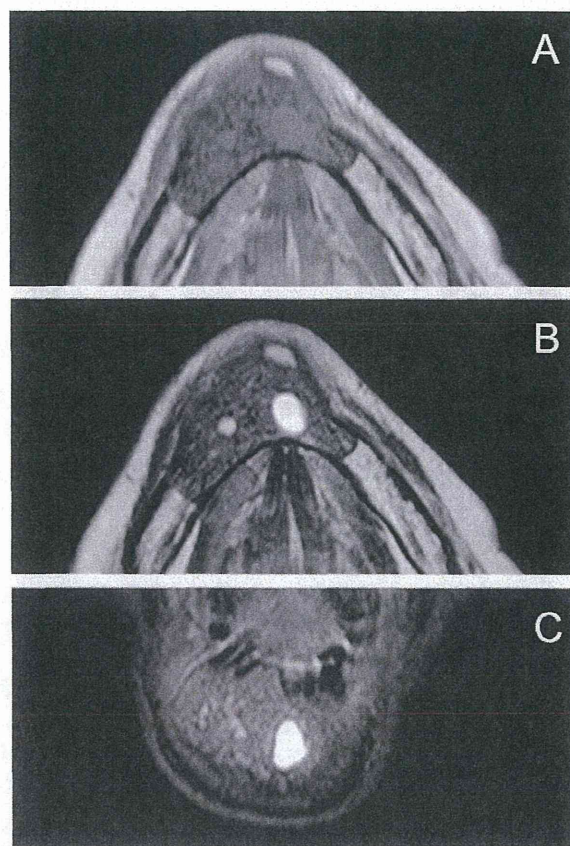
Magnetic resonance images. A, T1-weighted axial image. B, T2-weighted axial image. C, Short-T1 inversion recovery sequence coronal image.
